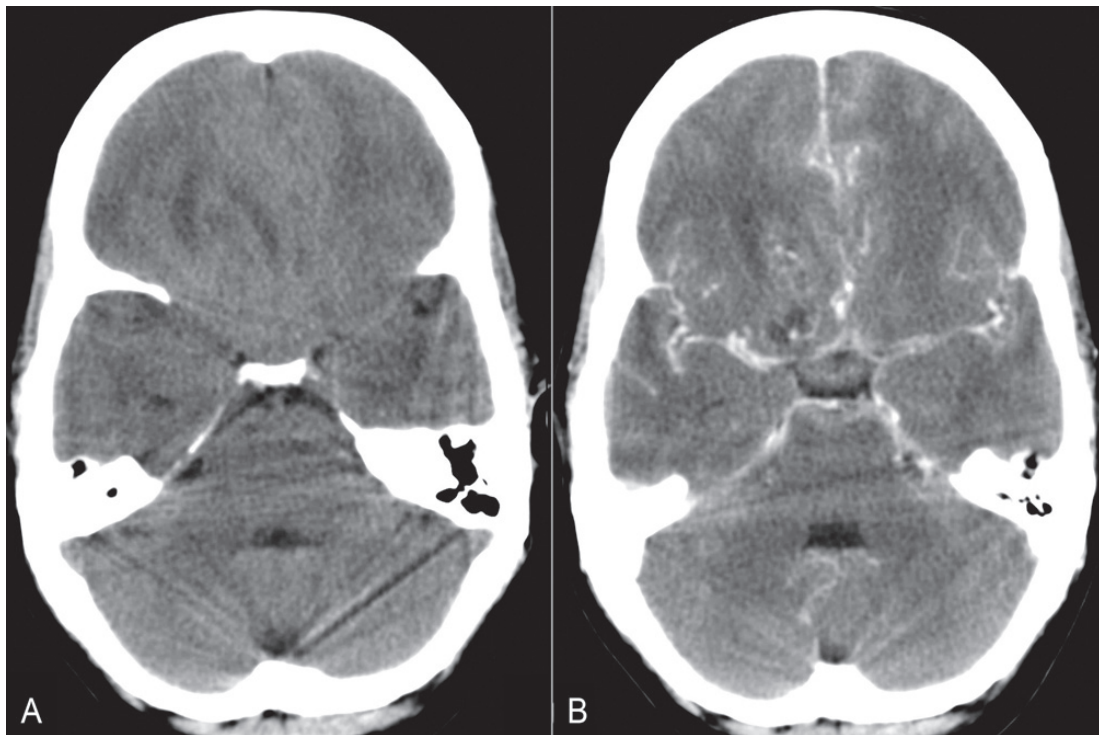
Pre contrast (A) and post contrast (B) axial computed tomography of brain of a 35 years old lady with CSF cytology confirmed neoplastic meningitis secondary to round cell carcinoma of the submandibular gland show diffuse brain edema and diffuse meningeal enhancement.
